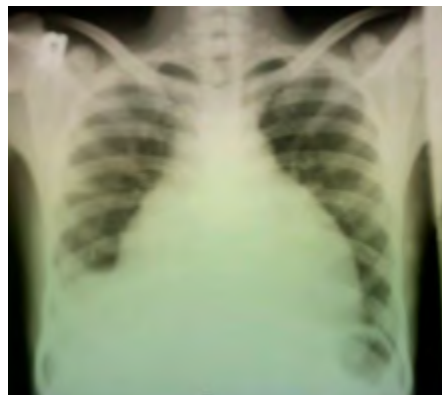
Chest X-ray postero-anterior view showing massive cardiomegaly due to pericardial effusion.
